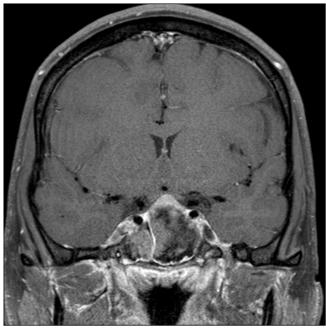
MRI Brain, T1 with contrast, coronal view demonstrates large sellar mass compressing the optic chiasm.
